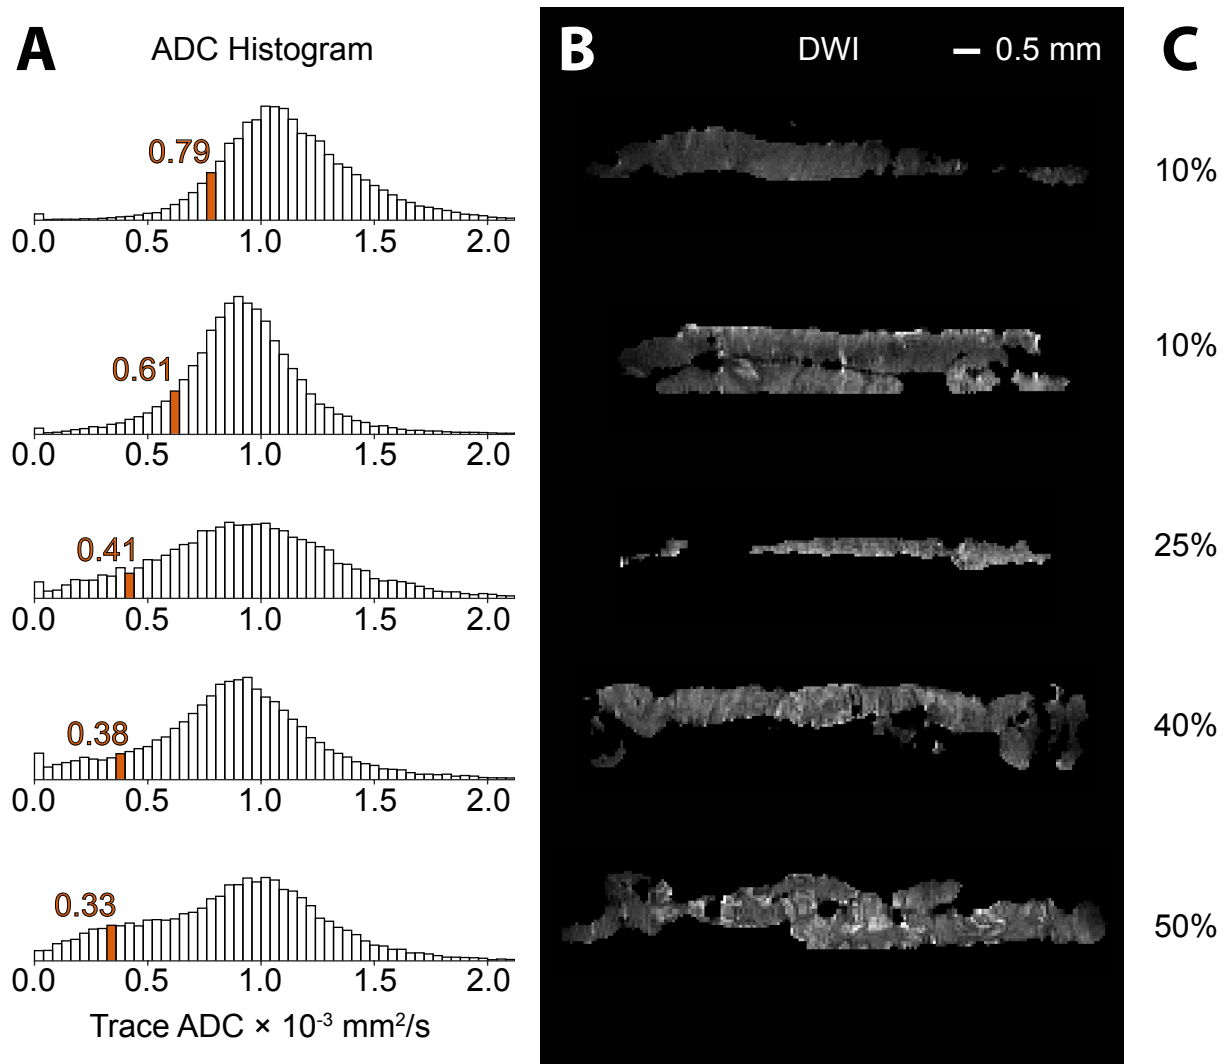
Results from ex vivo micro-DWI of prostate biopsy samples.
